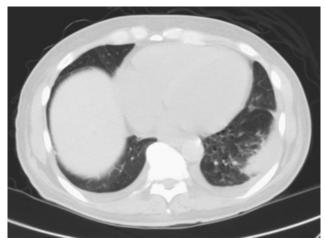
Computed tomogram shows a left-lower-lobe consolidation.
